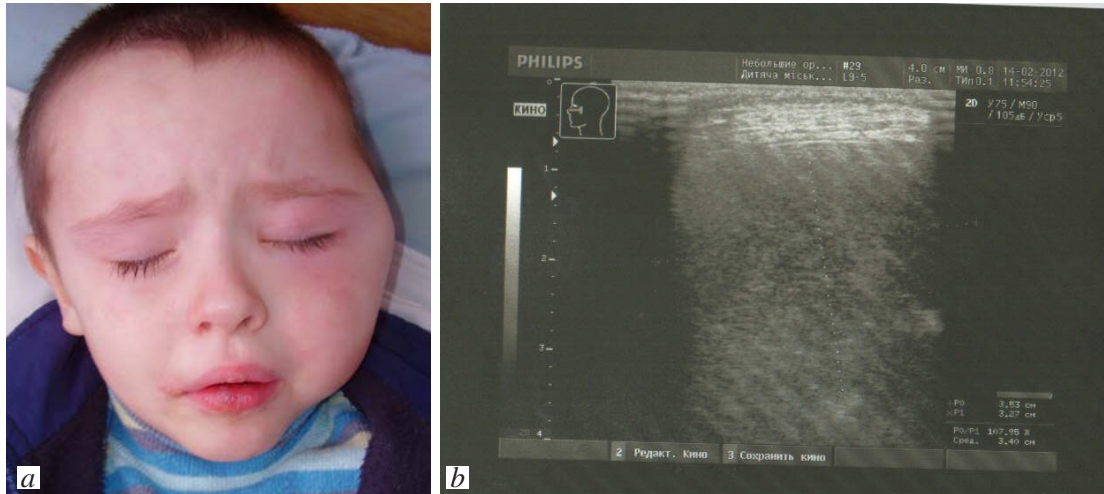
Appearance of patient S., 2.5 years old. Diagnosis: rhabdomyosarcoma of parameningeal localization with invasion to maxillofacial area tissues (a). Ultrasonography (b) identified heterogeneity of structure of left cheek tissues with areas of hyper- and hypoechogenicity
